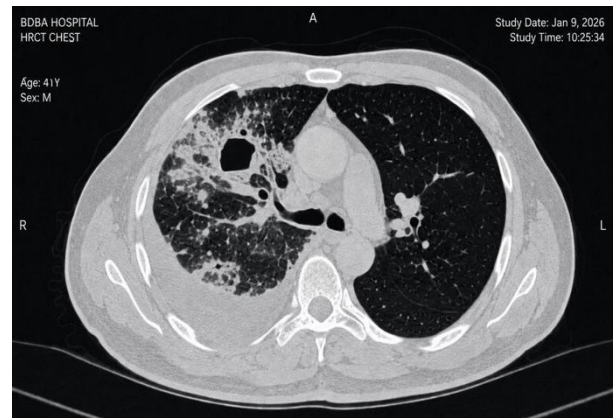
Axial HRCT chest image (lung window) showing a right upper lobe cavitory lesion with surrounding patchy consolidative opacities and associated right pleural effusion.
